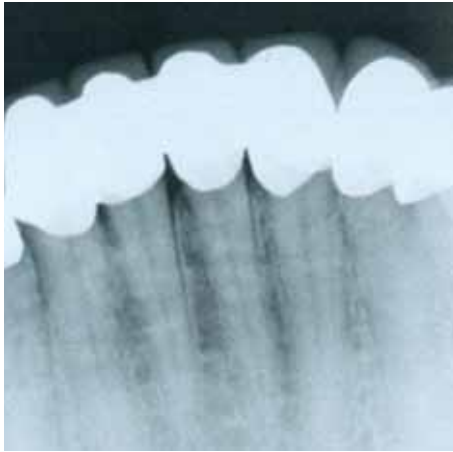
Periapical radiograph of lower anterior teeth.
